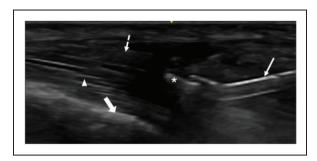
Long axis ultrasound view of first extensor compartment. The Trigger Finger Sono-Instrument® (TF-SI) (thin solid arrow) is introduced from distal to proximal through the entry point. Note the cutting part of the instrument highlighted by an hyper-echoic line (*). The instrument is progressively introduced over the tendon (arrowhead) up to the limit of the extensor retinaculum (dashed arrow). Distal radial cortex (heavy arrow).
